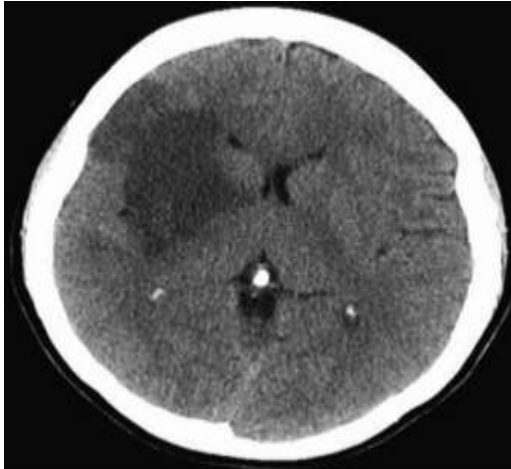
A 56 year old male patient known with DM, dyslipidemia, obese and significant (50%) right internal carotid artery stenosis, with postoperative left hemiplegia more in upper limb, CT brain showed right middle cerebral artery (upper branch) territory infarction.
